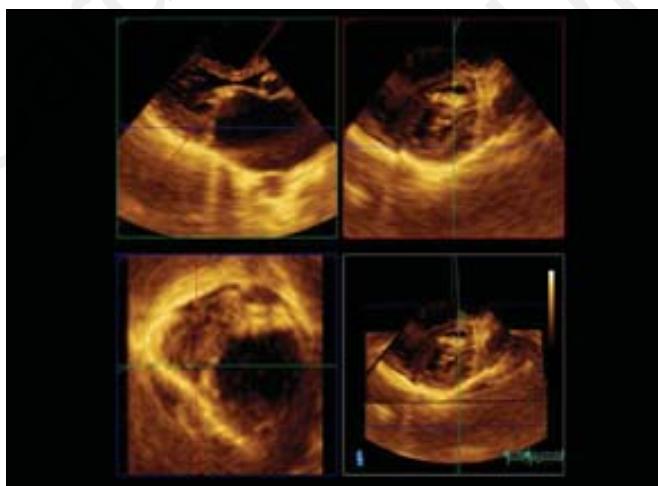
Mitral valve area planimetry using three-dimensional echocardiography in a patient with rheumatic mitral stenosis. Three-dimensional echocardiography allows accurate alignment of the imaging plane at the leaflet tips so that correct measurement of mitral valve area can be performed.
